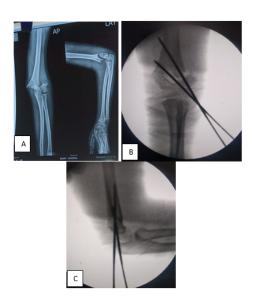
a: Preoperative x-ray; b: Post op x-ray (ap view); c: Post op x-ray (lateral view)
